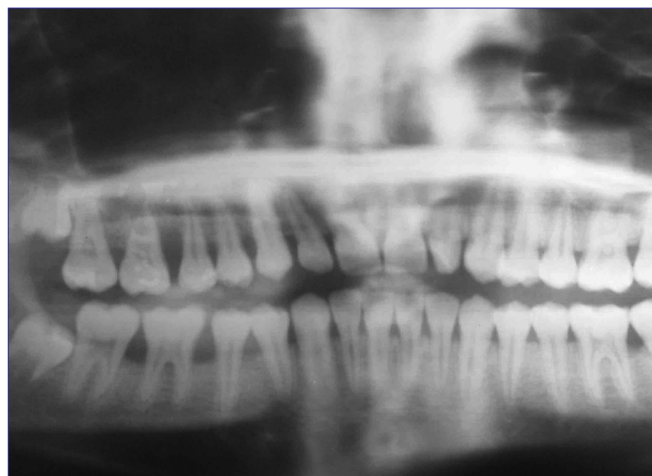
Radiographic picture
